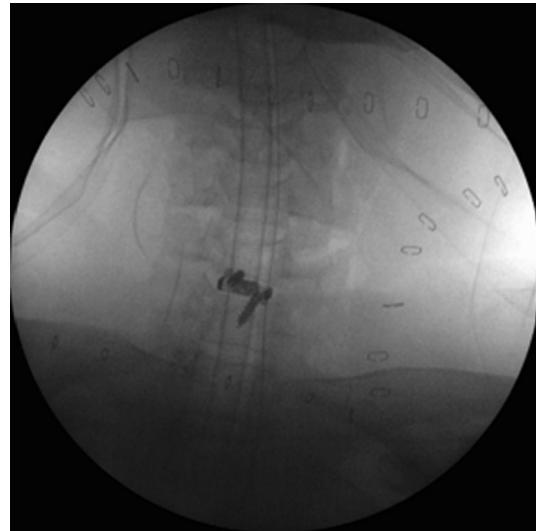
Intra-operative AP radiograph of ACDF
